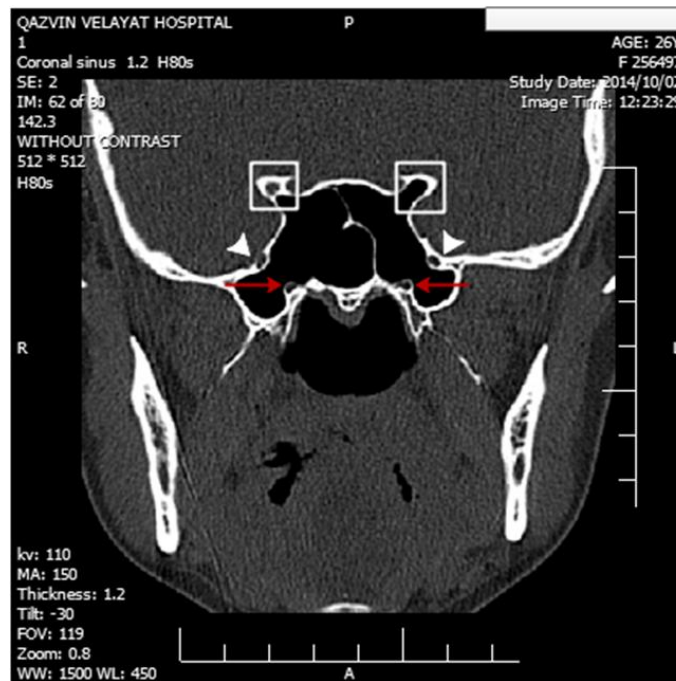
Coronal CT scan revealed Pneumatization (presence of air cells in the anterior clinoid processes) [rectangulars], Dehiscence (bone coverage missing in pterygoid canal) [red arrow] and also Protrusion (bone bulging around foramen rotundum)
